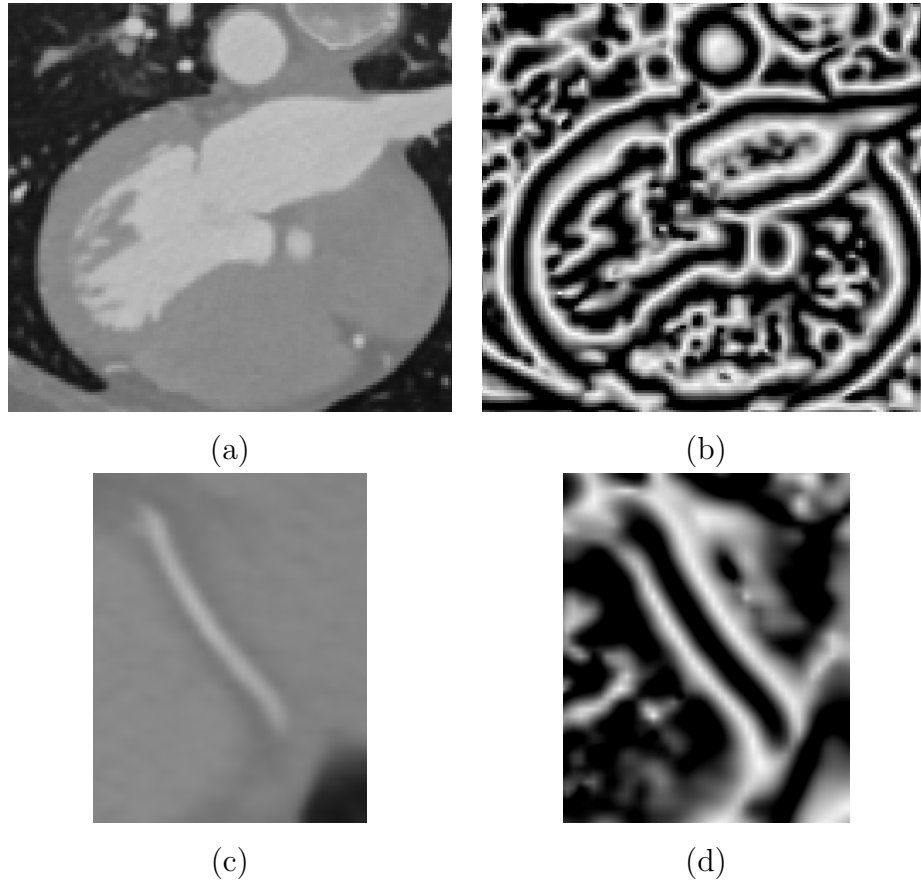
A CTA image (a) and its local phase image (b); A CTA image region containing right coronary artery segment (c) and its local phase (d).
